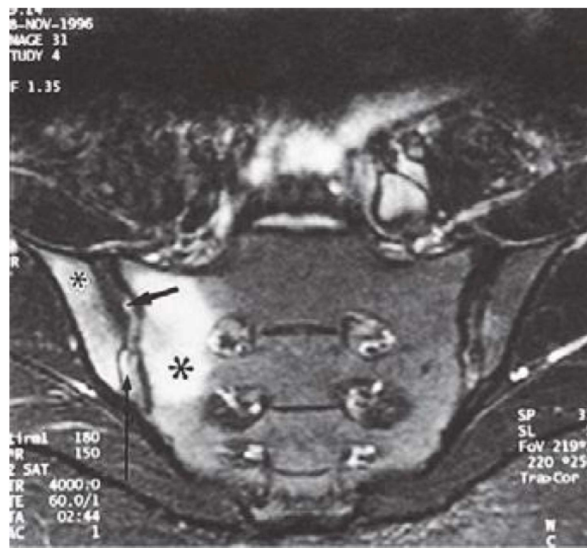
Early sacroiliitis in a patient with ankylosing spondylitis, indicated by prominent edema in the juxtaarticular bone marrow (asterisks), synovium and joint capsule (thin arrow), and interosseous ligaments (thick arrow) on a short tau inversion recovery (STIR) magnetic resonance image. (From M Bollow et al: *Zeitschrift für Rheumatologie* 58:61, 1999. Reproduced with permission.)
